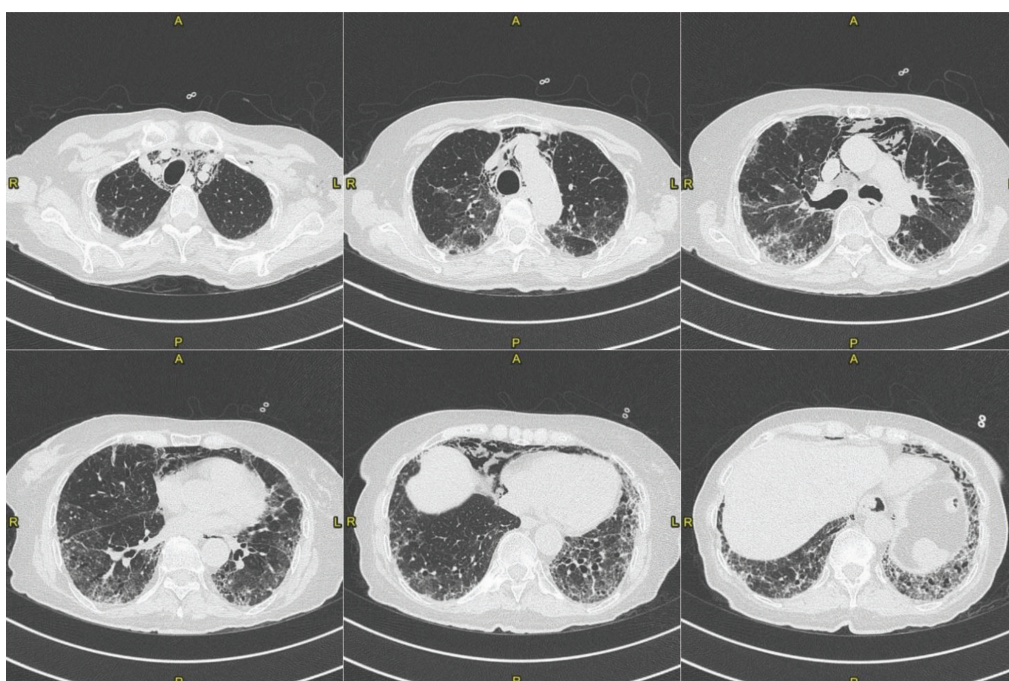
CT scan at the patient's discharge (June 2020): Ground glass opacities with patchy distribution, persistence of the basal fibrotic pattern, with traction bronchiectasis. Presence of pneumomediastinum. Visual score of 50%.
